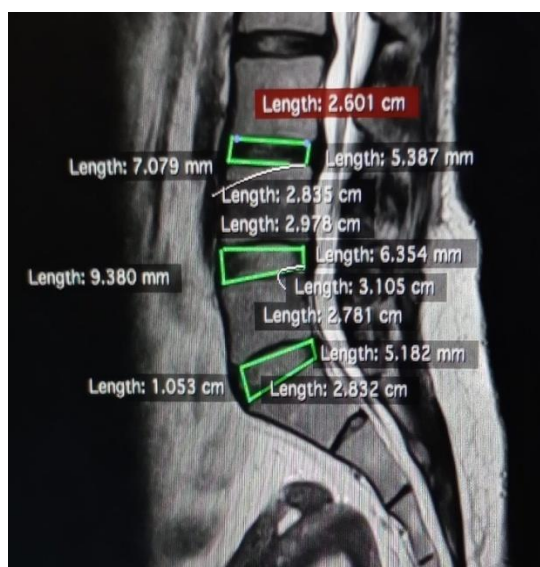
Measurement of IVDH on MR image by T2 sequence on sagittal plane.
